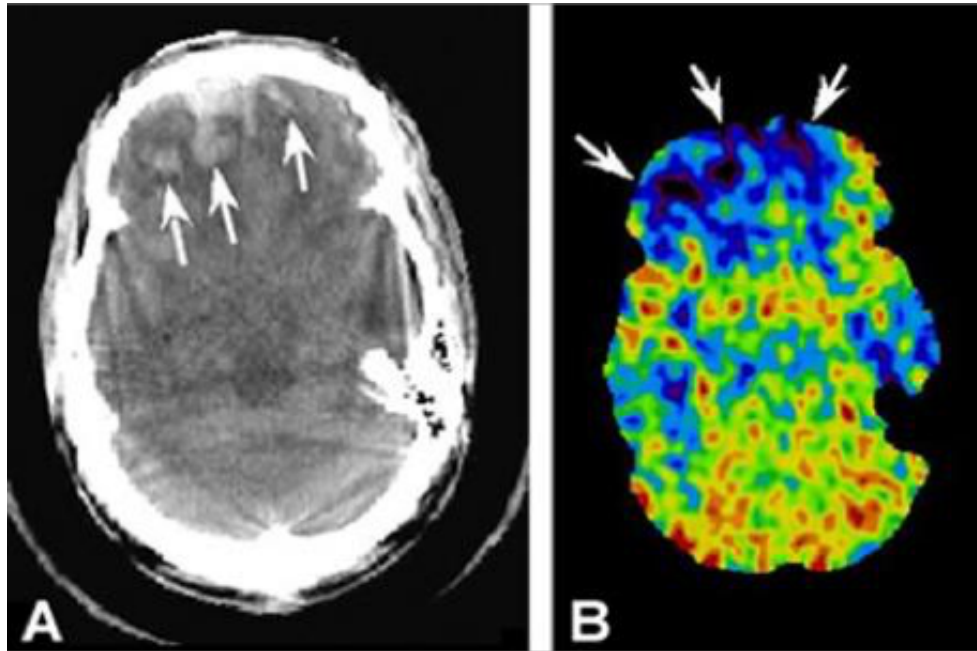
Comparison of a CT scan with a xenon blood-flow radionuclide scan. A. CT scan shows bifrontal contusions following severe head trauma (arrows). B. Companion CT scan showing xenon uptake demonstrates dark regions (arrows), indicating decreased perfusion in the contused brain [57].
